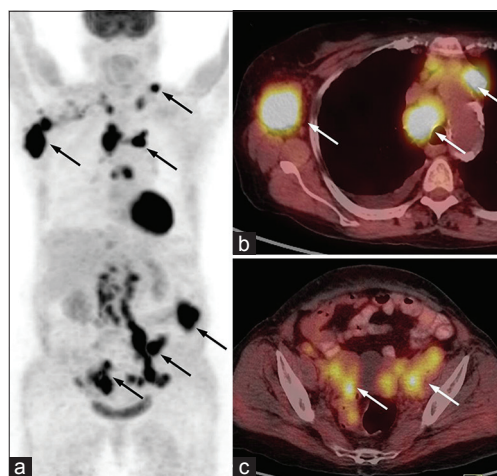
(a-c) A 67-year-old female with biopsy proven ovarian carcinoma. Maximum intensity projection positron emission tomography (PET) image (a) and transaxial PET/computed tomography images (b and c) revealed multiple enlarged ^{18}F -2-fluoro-2-deoxy-glucose avid cervical, axillary, mediastinal, retroperitoneal, mesenteric and pelvic metastatic lymph nodes (arrows)
